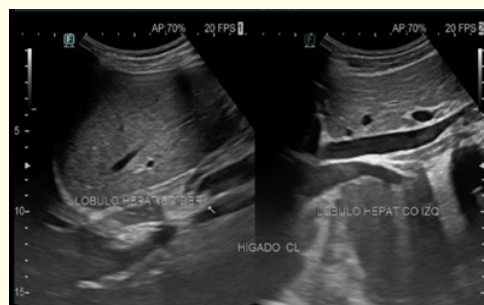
Normal liver and biliary tract ultrasound.
